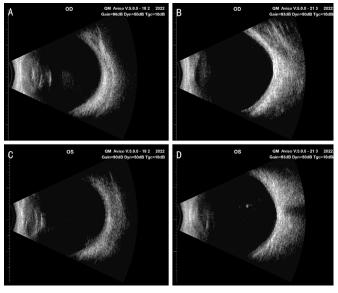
B-ultrasound image of the patient before and after surgery Right eye before (A) and after (B) surgery; Left eye before (C) and after (D) surgery.
